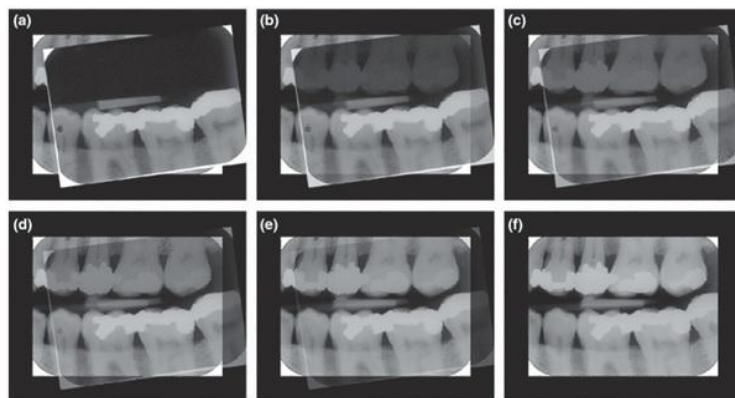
At post-mortem examination, an AM radiograph was made available (f). A PM radiograph of the corresponding portion of the mandible was secured, attempting to duplicate the geometry of the AM image as closely as possible. The two radiographs are digitally overlaid and aligned, maintaining the original aspect ratio. Pictures (a)–(f) show how the opacity of the overlying (PM) image is progressively reduced to show the features of the AM image below. This is performed in real-time if required before a tribunal, or included in a Statement of Evidence in the form shown above. (a) PM radiograph opacity 100%; (b) PM radiograph opacity 80%; (c) PM radiograph opacity 60%; (d) PM radiograph opacity 40%; (e) PM radiograph opacity 20%; (f) PM radiograph opacity 0%.¹³⁶
